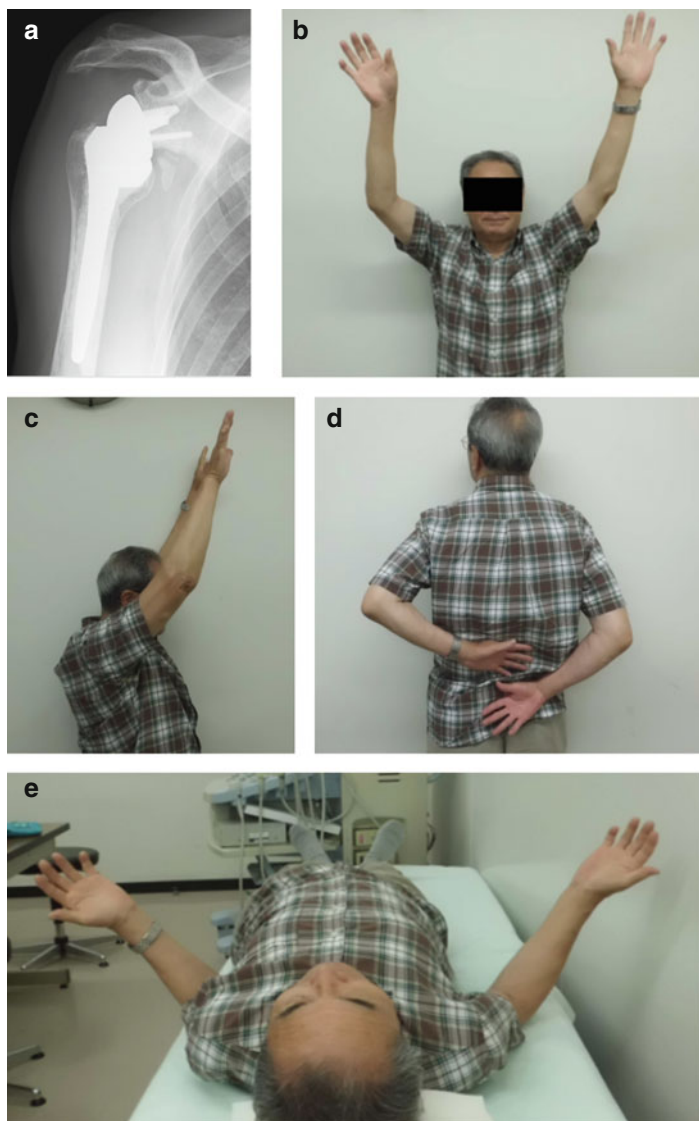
Images obtained after reverse shoulder arthroplasty for cuff tear arthropathy. (a) Anteroposterior (AP) radiograph shows humeral and glenoid implants in place. Clinical photographs show postoperative active range of motion in abduction (b), forward elevation (c), internal rotation (d), and external rotation (e)
